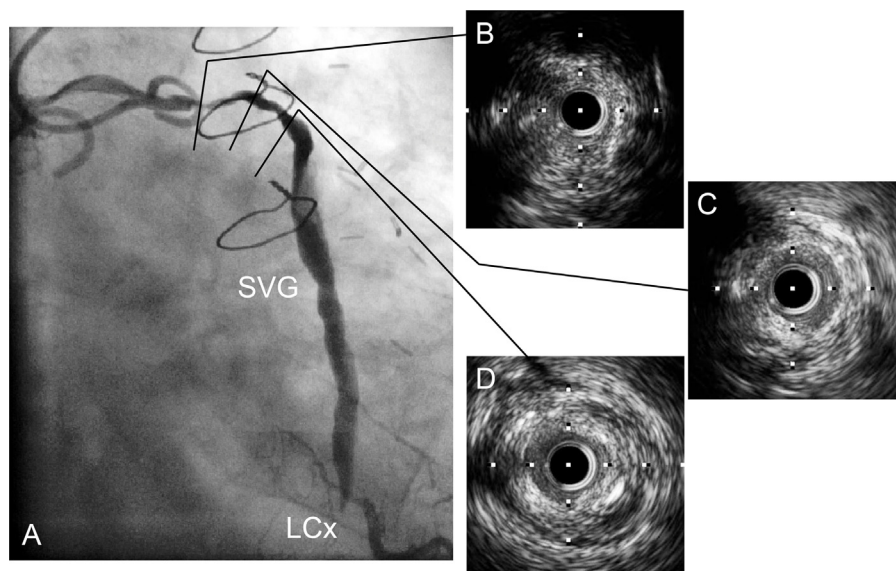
Baseline angiography and IVUS findings before percutaneous coronary intervention. (A) Severe narrowing of the proximal SVG; (B through D) IVUS showed an abundance of attenuated plaque in the lesion of the SVG. (B) Ostial lesion; (C) mid of the lesion; (D) distal site of the lesion. IVUS, intravascular ultrasound; LCx, left circumflex artery; SVG, saphenous vein graft.
